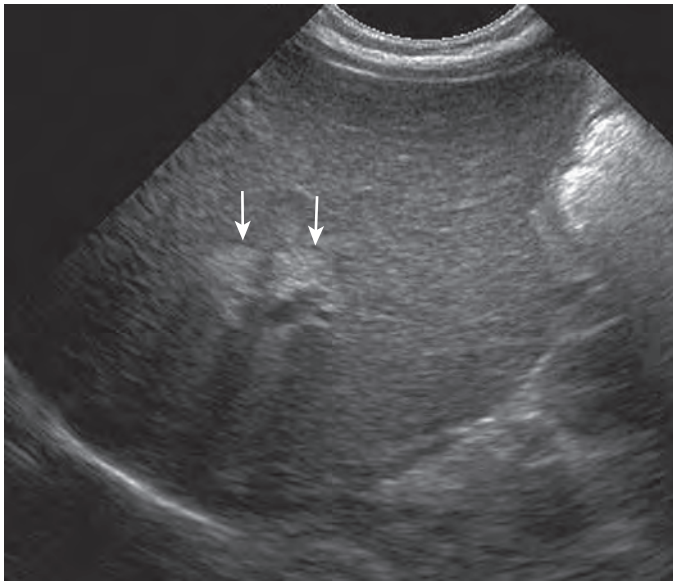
Biliary atresia: triangular cord sign on ultrasound. The triangular cord sign describes the fibrotic, obliterated common bile duct in infants with biliary atresia. It is seen as a focal hyperechoic area just cephalad to the main portal vein bifurcation, or it can be measured as the echogenic anterior wall of the right portal vein (arrows). The hypoechoic area within this is a branch of the right hepatic artery. (Courtesy Myung-Joon Kim, MD, Yonsei University College of Medicine, Severance Hospital, Seoul, Korea.)
